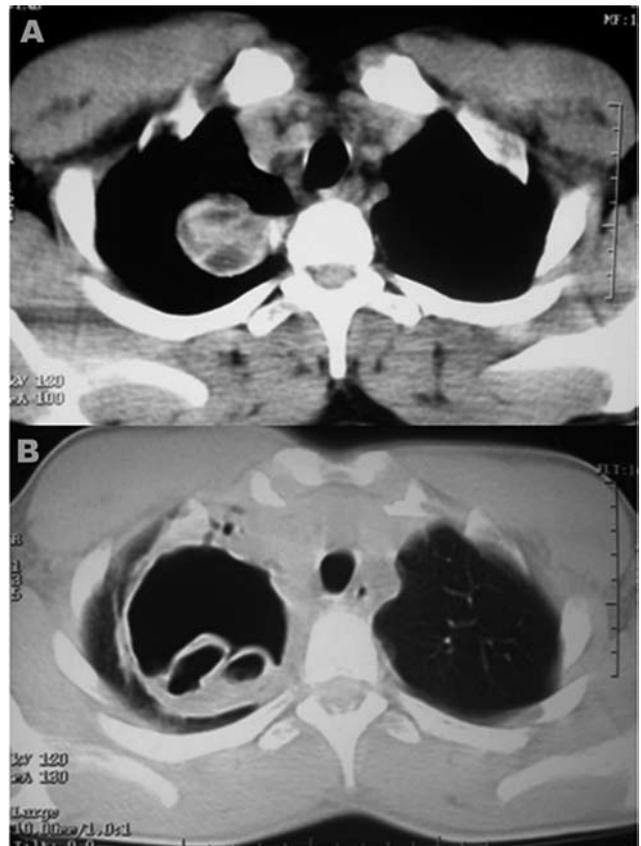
(a) Thorax CT revealed an intact cystic lesion in the right upper lobe. This CT scan shows the hydatid disease before albendazole treatment. (b) CT scan of the perforated hydatid cyst belongs to the same patient. The hydatid disease became complicated after albendazole treatment.
